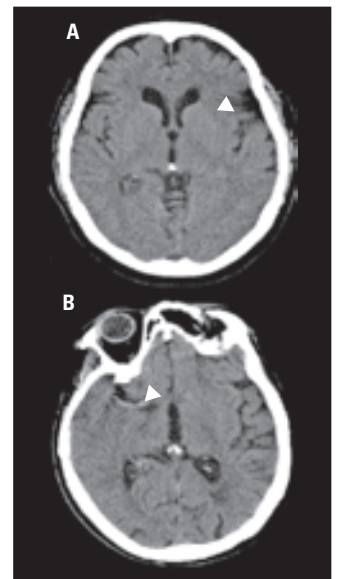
CT Images of Early Infarct – showing (A) absence of left insular ribbon (B) hyperdense artery
